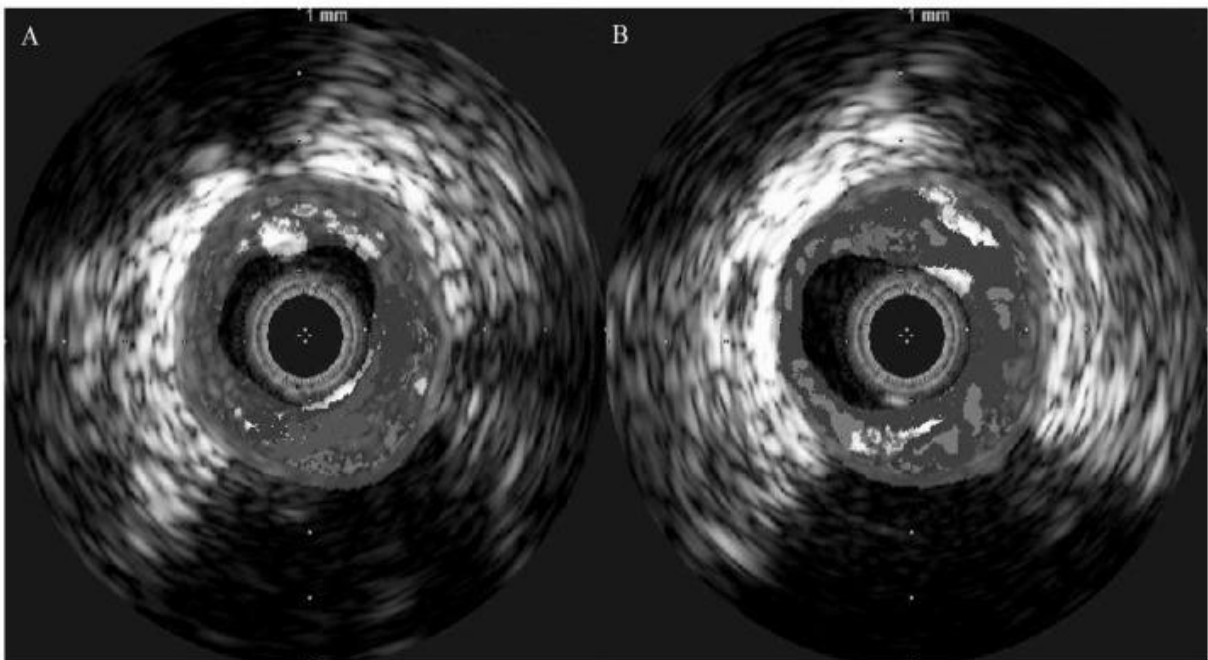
Intravascular Ultrasound (IVUS) of 2 different plaques (A) Unstable plaque. (B) stable plaque . (Guo. S, et al. 2012)
